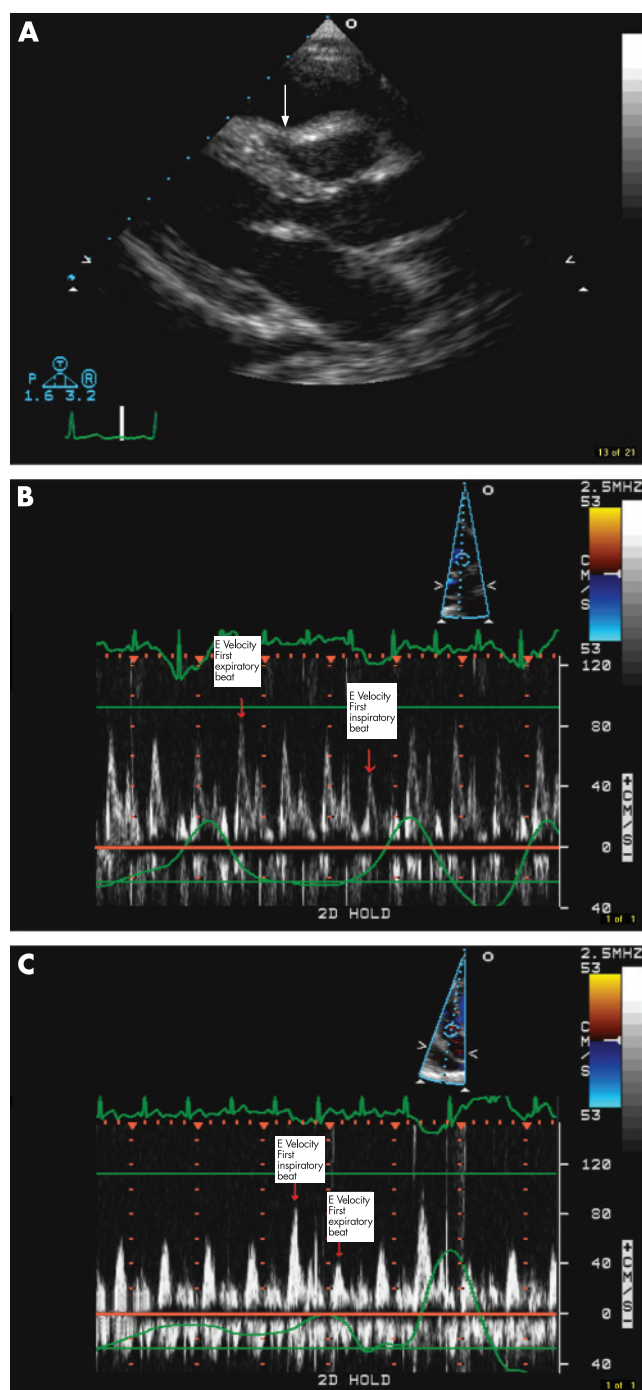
(A) Transthoracic parasternal long axis echocardiographic image showing a large pericardial effusion. Arrow points to diastolic right ventricular compression. (B and C) Pulsed wave Doppler of the mitral and tricuspid valves showing increased respiratory variation in the same patient in panel A, who clinically had signs of cardiac tamponade.
